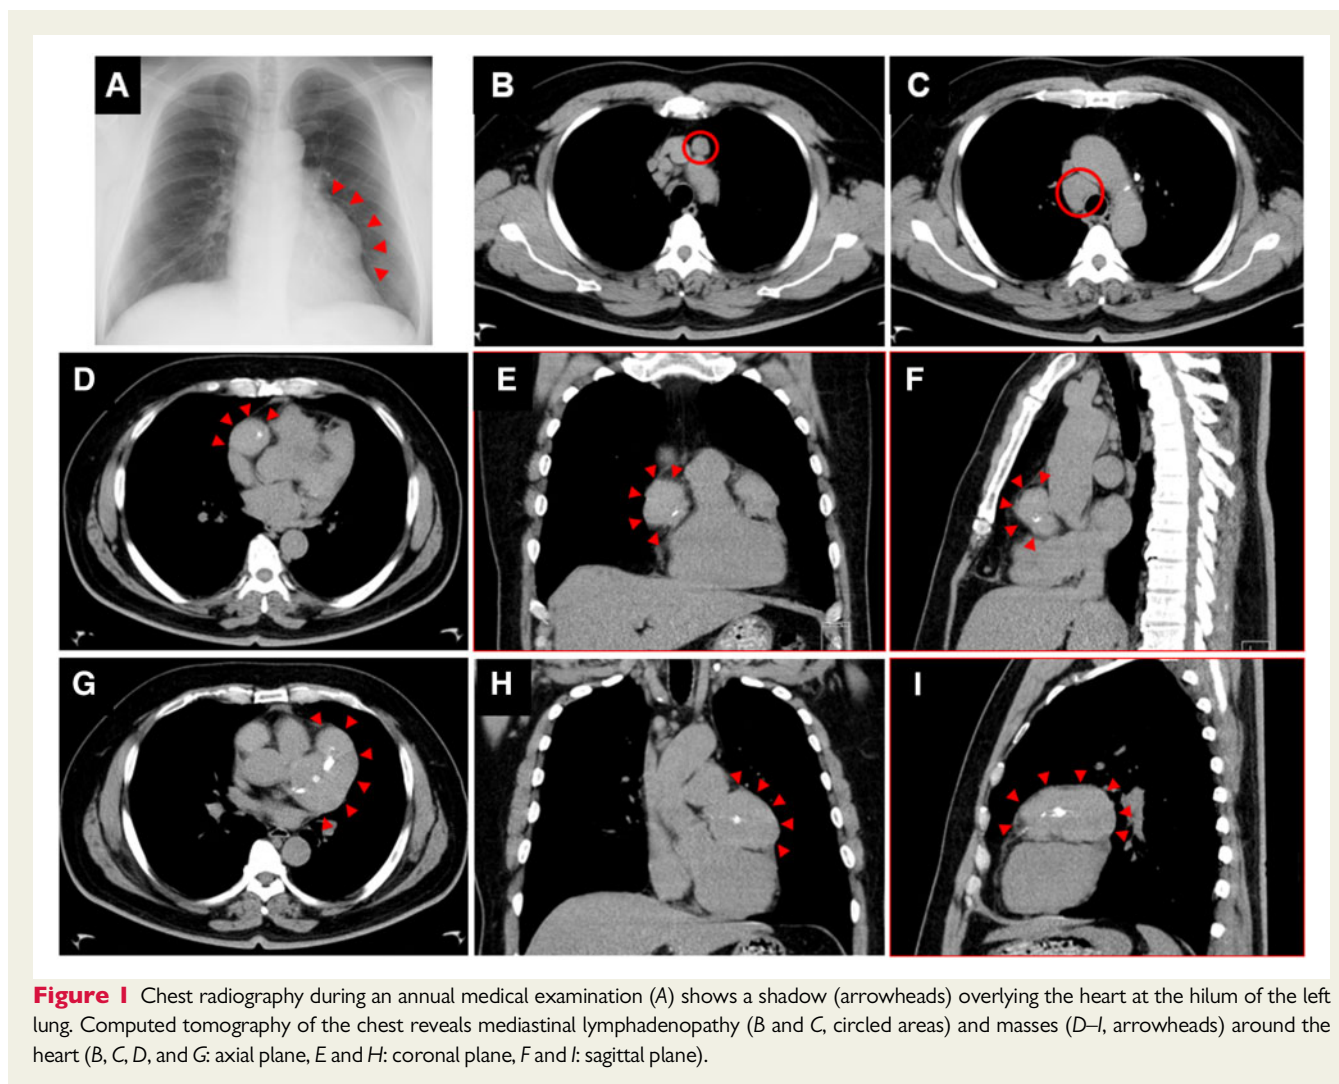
Chest radiography during an annual medical examination (A) shows a shadow (arrowheads) overlying the heart at the hilum of the left lung. Computed tomography of the chest reveals mediastinal lymphadenopathy (B and C, circled areas) and masses (D–I, arrowheads) around the heart (B, C, D, and G: axial plane, E and H: coronal plane, F and I: sagittal plane).
